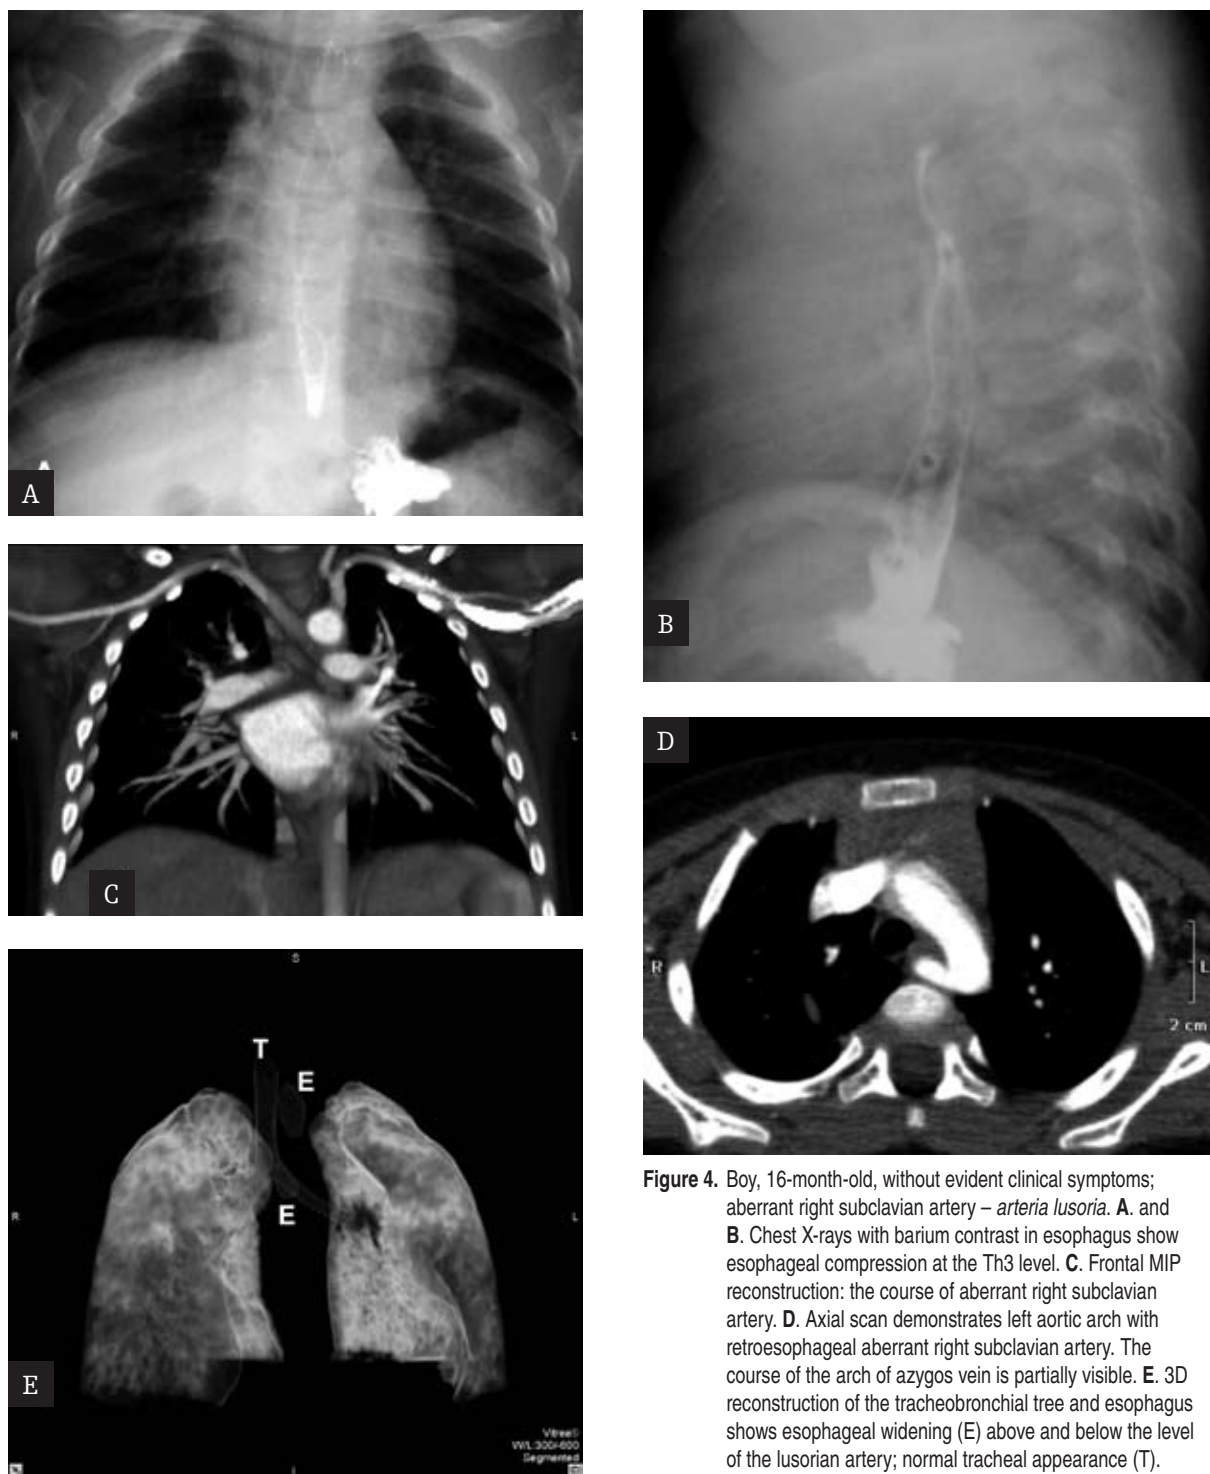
Boy, 16-month-old, without evident clinical symptoms; aberrant right subclavian artery – *arteria lusoria*. A. and B. Chest X-rays with barium contrast in esophagus show esophageal compression at the Th3 level. C. Frontal MIP reconstruction: the course of aberrant right subclavian artery. D. Axial scan demonstrates left aortic arch with retroesophageal aberrant right subclavian artery. The course of the arch of azygos vein is partially visible. E. 3D reconstruction of the tracheobronchial tree and esophagus shows esophageal widening (E) above and below the level of the lusorian artery; normal tracheal appearance (T).
